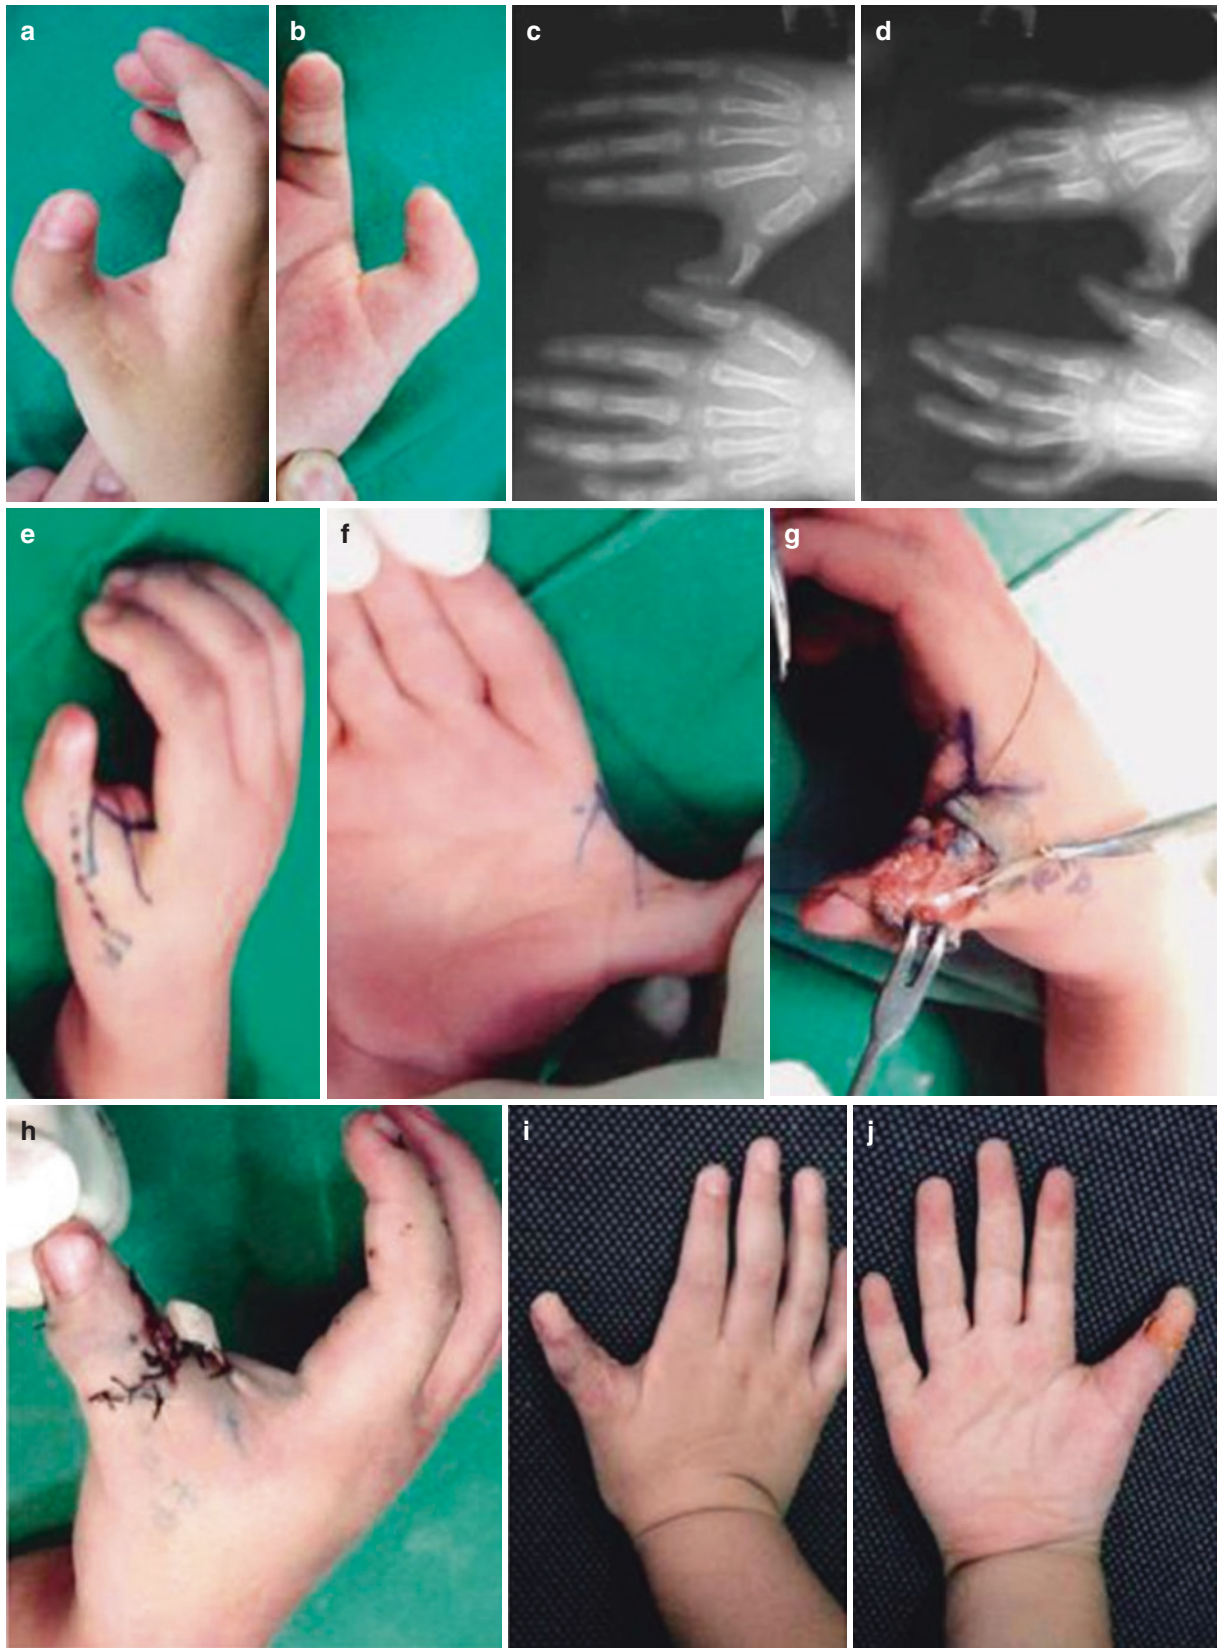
Case one. (a, b) Hand appearance before operation. (c, d) X-ray findings before operation. (e, f) Design of skin incisions for thumb web expansion during the surgery. (g) Phalangeal osteotomy and correction and tendon repair and reconstruction. (h–j) Hand appearance after operation
